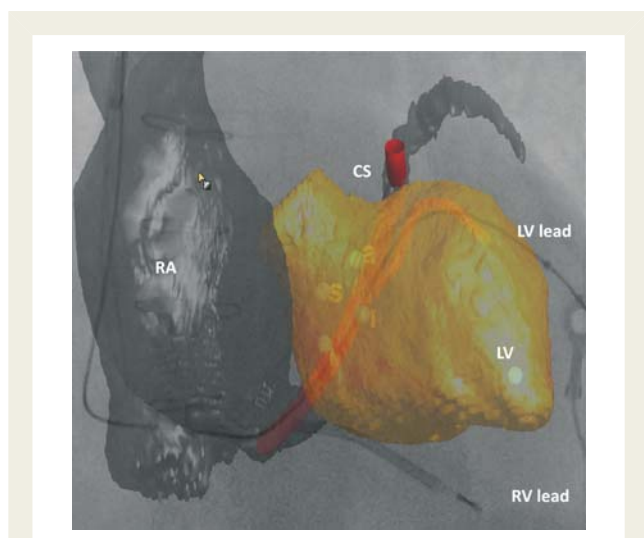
Computed tomography–fluoroscopy-integrated image. The figure shows an integrated image of a cardiac computed tomography with fluoroscopy. A reconstructed coronary sinus (CS) is seen with the left ventricular (LV) lead. The right ventricular (RV) lead is seen at the apex of the right ventricle. RA, right atrium (adapted from Truong et al).³⁶
